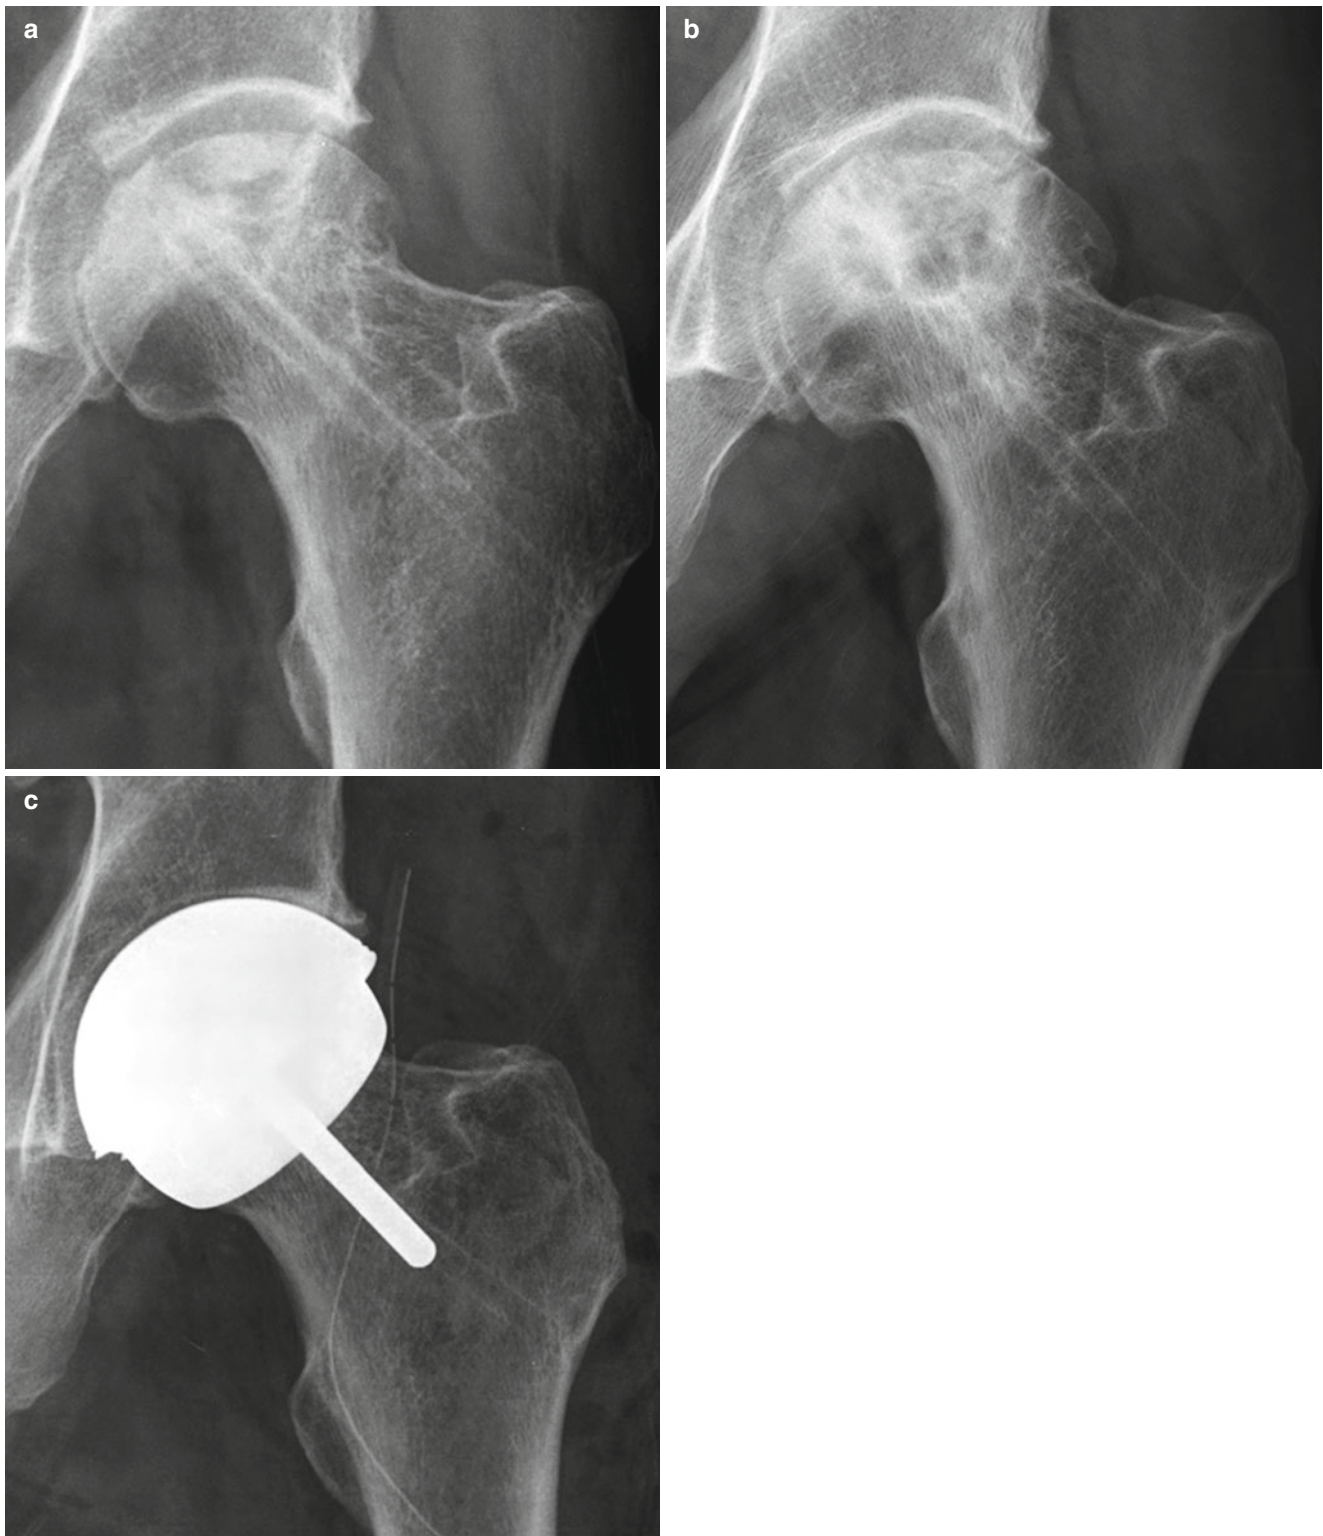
Serial radiographs of left hip anteroposterior views in a 46-year-old man with ON initially treated by core decompression. (a) Left femoral head reveals heterogeneously sclerotic lesion at the superior aspect, with subchondral collapse. Narrow radiolucent tubular area with sclerotic rim crossing femoral head-neck-greater trochanter means
